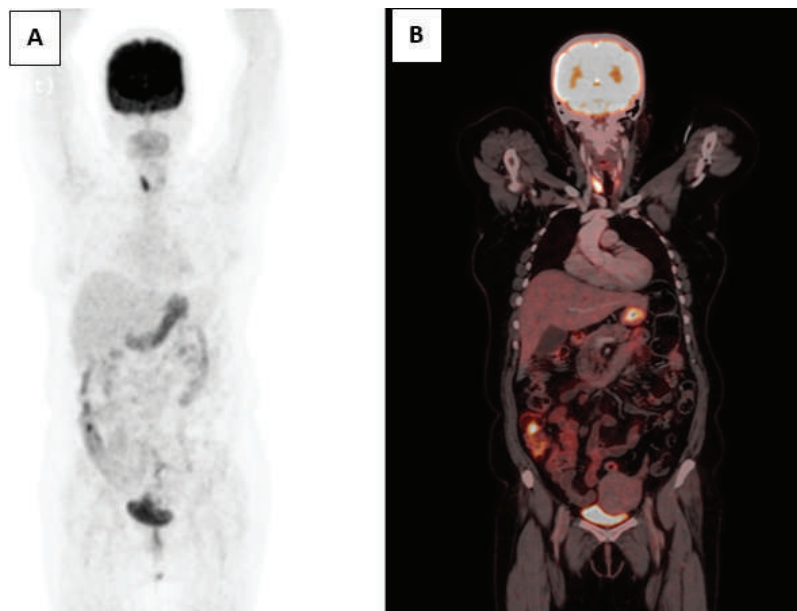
Post-therapy ¹⁸F-FDG fused PET-CT Maximum Intensity Projection (MIP) image (A) and fused ¹⁸F-FDG PET-CT coronal view (B) demonstrating complete morpho-metabolic regression of the previously noted thyroid mass, consistent with excellent therapeutic response. Residual diffuse FDG uptake in the right thyroid lobe is likely attributable to thyroiditis.
